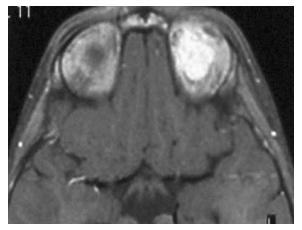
T1-weighted, fat suppressed axial MR image showing recurrent intraorbital Rb with markedly high signal after gadolinium enhancement.
